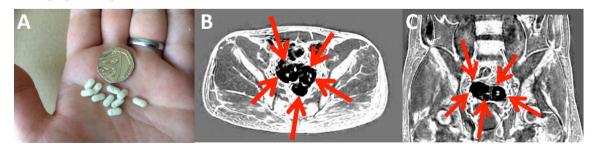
A) Example of mini-capsules; B-C) MRI images of the mini-capsules in the distal colon of a healthy volunteer.
